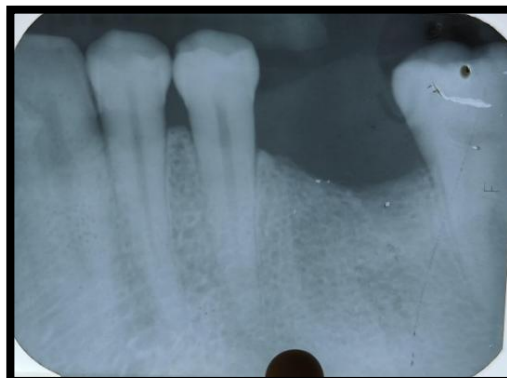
Radiographic examination showing localised Bone loss with respect to 46 tooth region.
